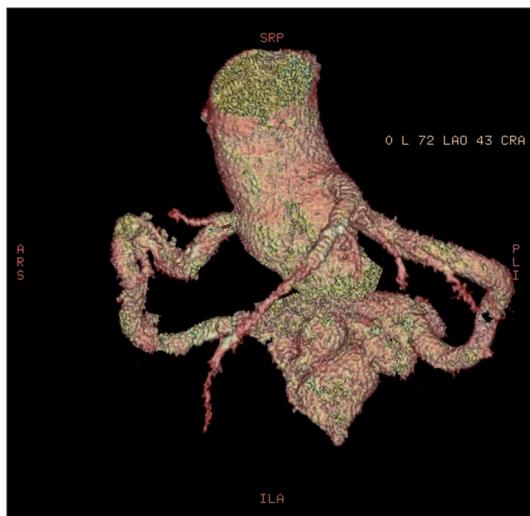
CT angiography. Ectatic right and left circumflex coronary arteries leading to the huge aneurysm, which is drained to the coronary sinus and right atrium.
